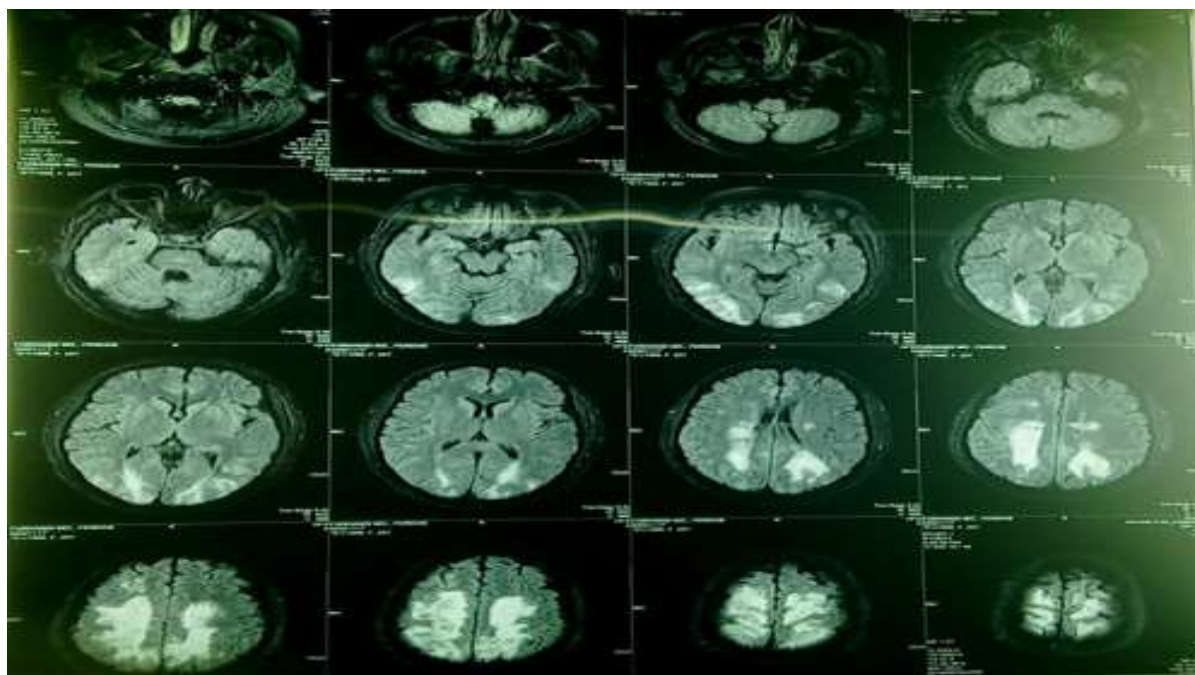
MRI : bilateral symmetrical high signal intensity change in white matter of parieto-occipital lobes
